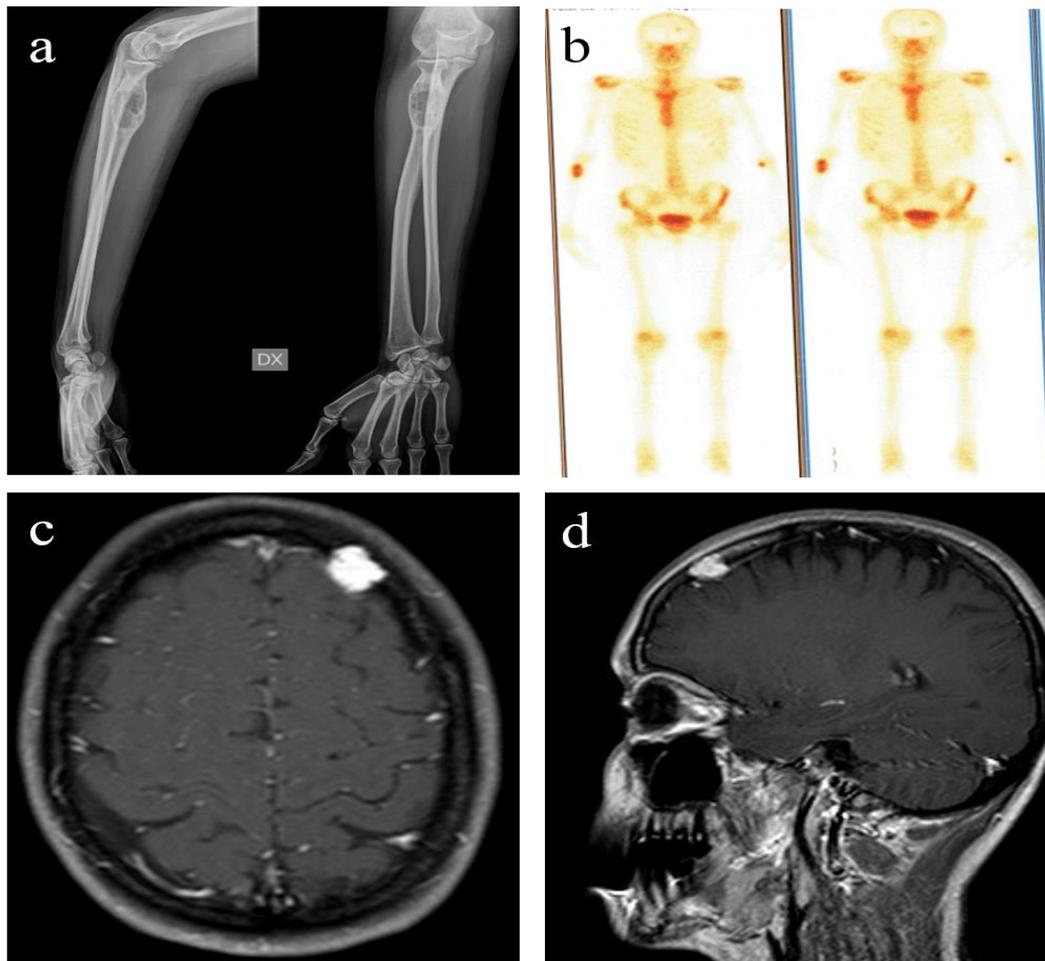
a Radiographs show a lytic and expansile intramedullary lesion of the proximal radius. b Bone scan shows an increased uptake in the proximal radius and the left frontal skull. c Axial T1-weighted post contrast enhanced MR image showing a lobulated extra-axial enhancing lesion from left frontal skull with hyperintensity. d Coronal T2-weighted image shows a small hyperintense extra-axial lesion of the left frontal region.
